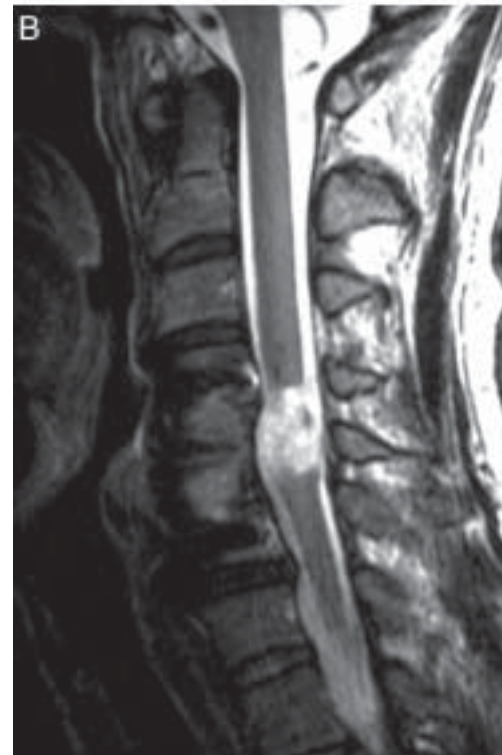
Both T1-(A) and T2-weighted images (B) at 3 months after the transplantation shows a cavity formation at C5 level in the spinal cord.
